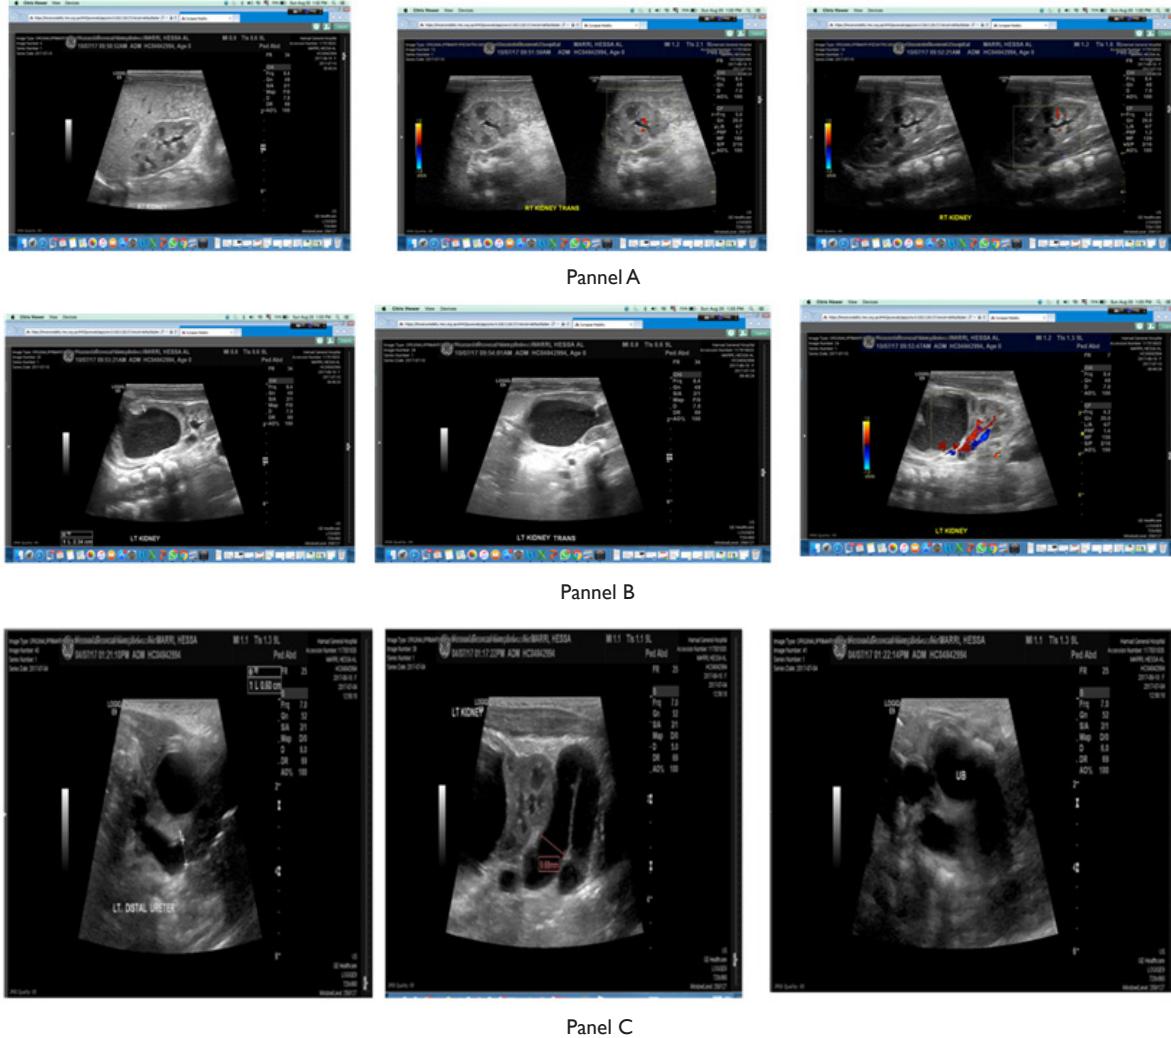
Post natal Ultrasound.
